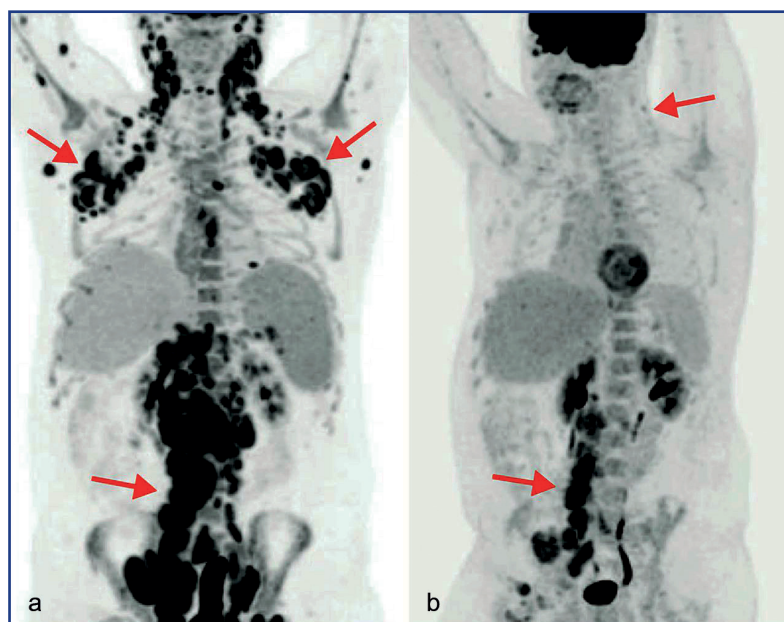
Score 5 on the 5D scale: a – before treatment, b – intermediate PET/CT. Arrows indicate affected areas [20]
